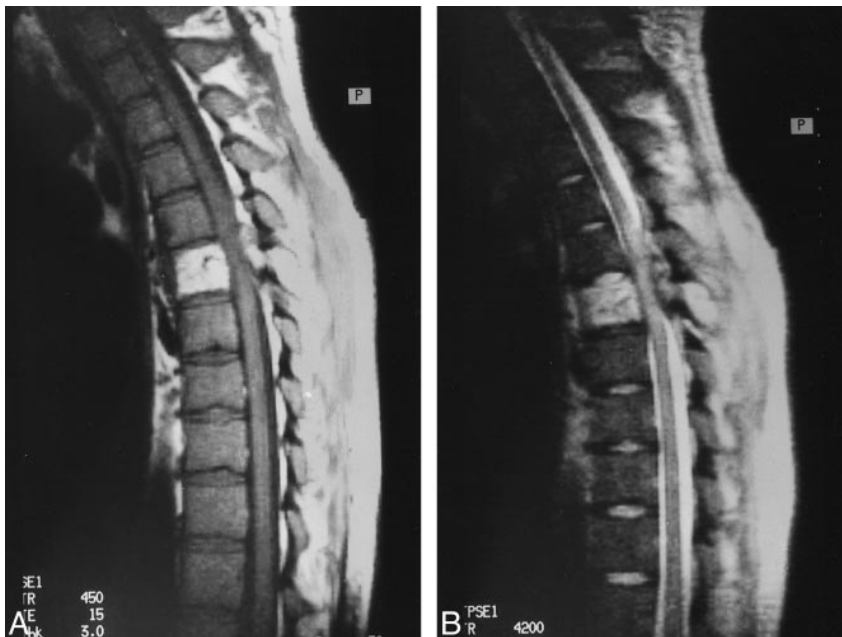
A 35-year old man who presented with paraparesis. T1- (A) (450/15/3, [TR/TE/excitations]) and T2-weighted (B) (4200/90/1) sagittal MR images show a typical hemangioma at midthoracic level. The posterior elements also are involved, and the spinal canal is compromised. Note the presence of hyperintense signal within the spinal cord on the T2-weighted image.
